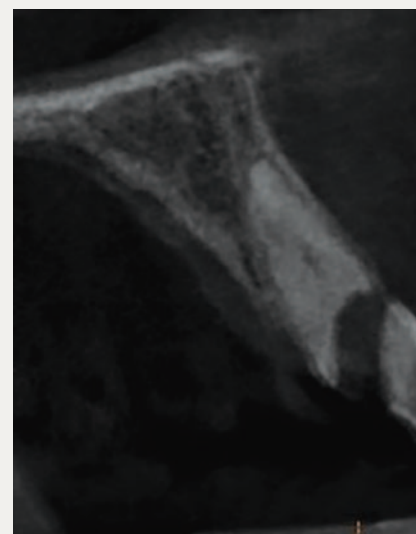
Sagittal section of CBCT.
